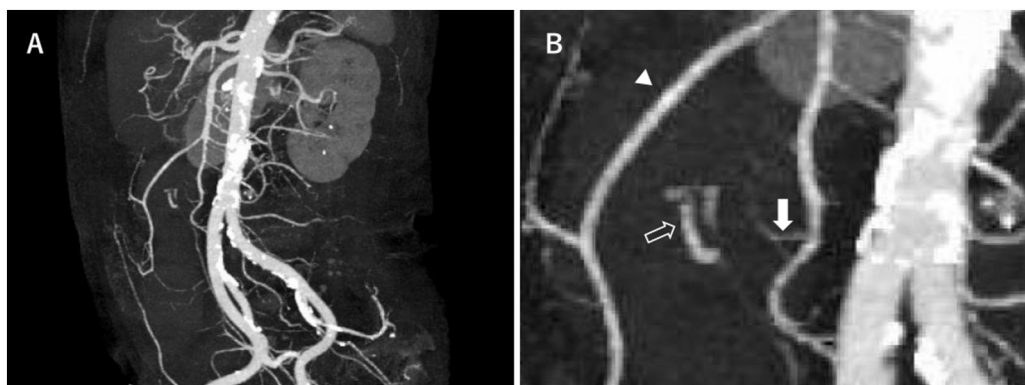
The CTA image of contrast extravasation from the branch of the superior mesenteric artery shown in Fig.1, A-1,2. The contrast extravasated from the branch of the superior mesenteric artery. Arrows indicate extravasation from the superior mesenteric artery branch.
